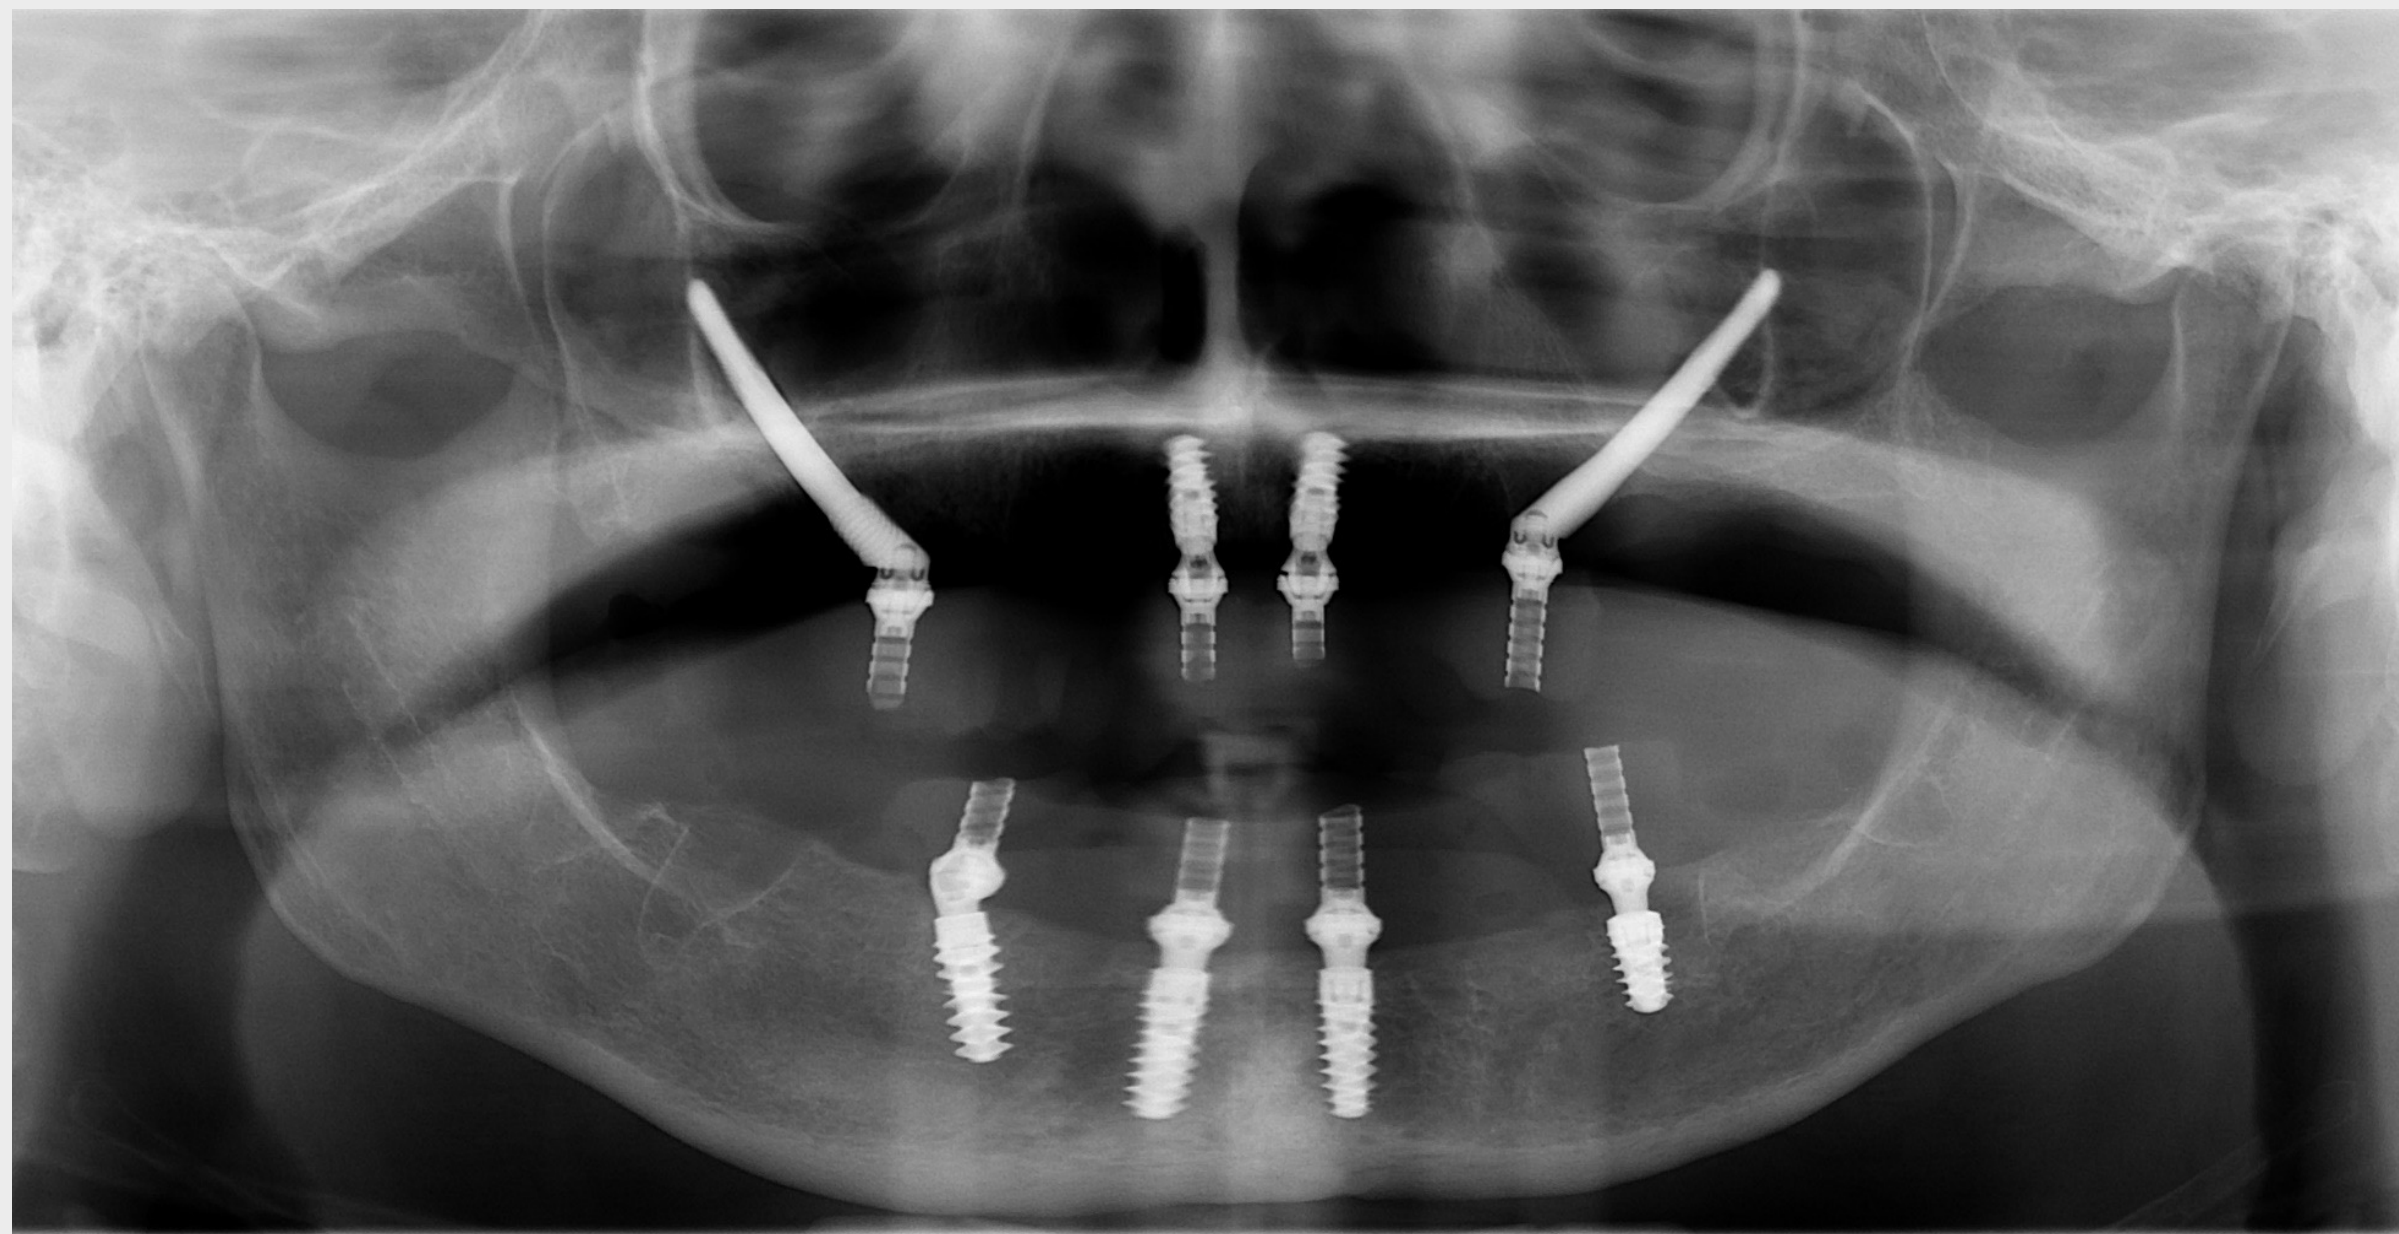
A post-operative panoramic radiograph was recorded to verify the adequate placement and positioning of the implants. The AP distribution of the 4 implants was ideal for the mechanical distribution.
